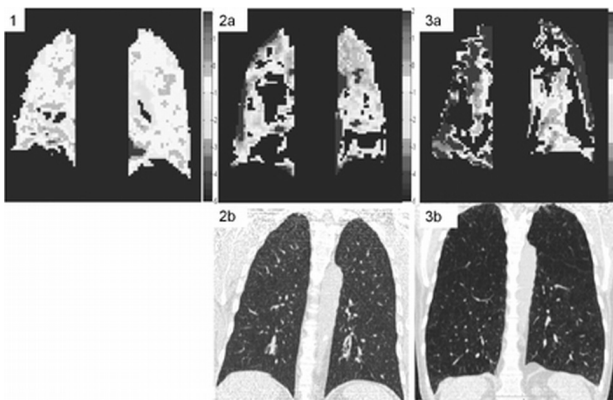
V/Q map of a male healthy subject (69 yrs, FEV1%=117%). Fig 2a and 2b: the V/Q map and matched CT image of a male COPD patient without emphysema (64yrs, FEV1%=65%, LAA%=0.74%). Fig 3a and 3b: the V/Q map and matched CT slice of a male COPD patient with emphysema (63yrs, FEV1%=26%, LAA%=41.78%). CT was not performed in healthy subjects.
